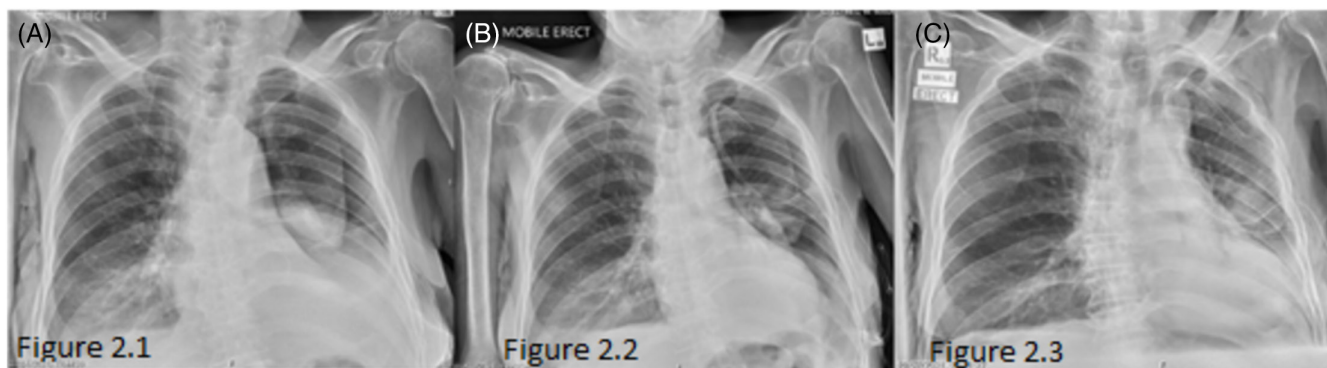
A (top right)—Chest x-ray day 2 of ICC—moderate left-sided hydropneumothorax. (B) (top middle)—Chest x-ray after the first blood pleurodesis demonstrating persistent pneumothorax. (C) (top left)—Chest x-ray after the third blood pleurodesis demonstrating the expansion of the left lung. (D) (bottom)—Data from the portable suction unit (PSU) Rocket TM device after the first dose of autologous blood patch. This demonstrates a reduction in the rate of air leak from ICC following the 2nd and 3rd autologous blood patch doses. There was an ongoing observed reduced air leak (‘less bubbling’), although the flow rate through ICC increased slightly on day 3, a successful trial of clamping was performed and ICC was removed, with only a minor increase in air leak from IPC, which settled after the removal of suction. Air leak never visually returned to pre-blood patch levels and there was no increase in pneumothorax size on serial radiographs upon clamping the ICC.
